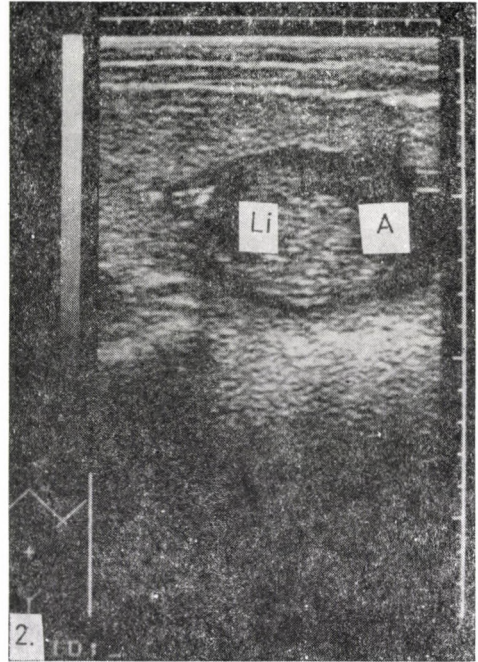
Ultrasonography. The transversal section at the level of the abdomen demonstrates the presence of ascites (A) between the liver (Li) and the abdominal wall
